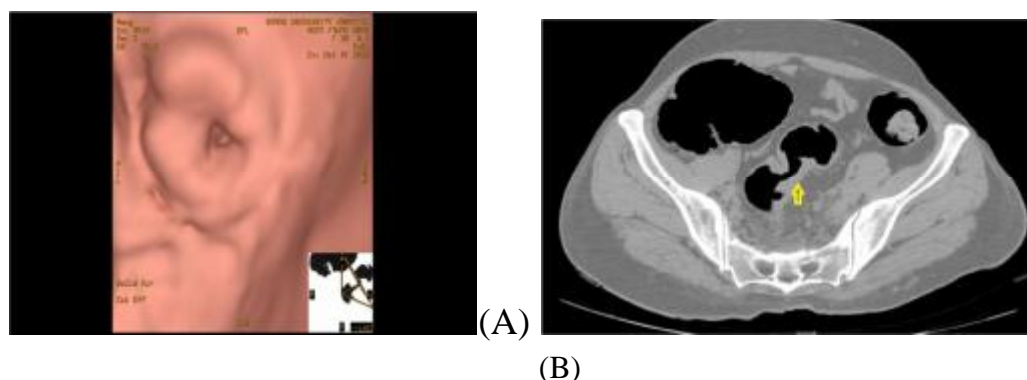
Stenotic cancer of the sigmoid colon. (a) 3D endoluminal image shows an irregular, circular, stenotic filling defect (arrow). (b) Supine sagittal contrast-enhanced CT image shows circular wall thickening (arrow).
